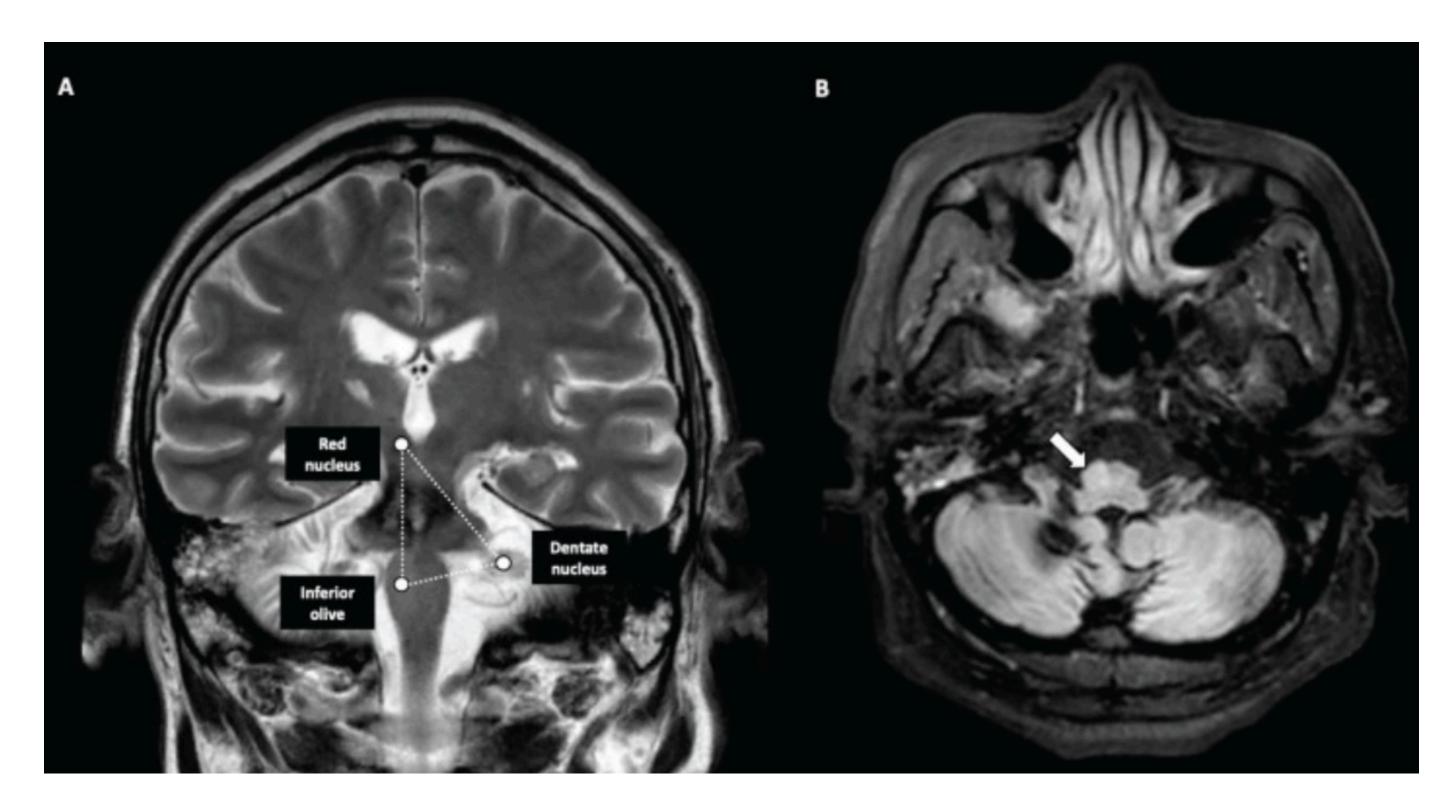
Example MRI of anoxic lesion within the guillain mollaret triangle causing laryngeal myoclonus¹
